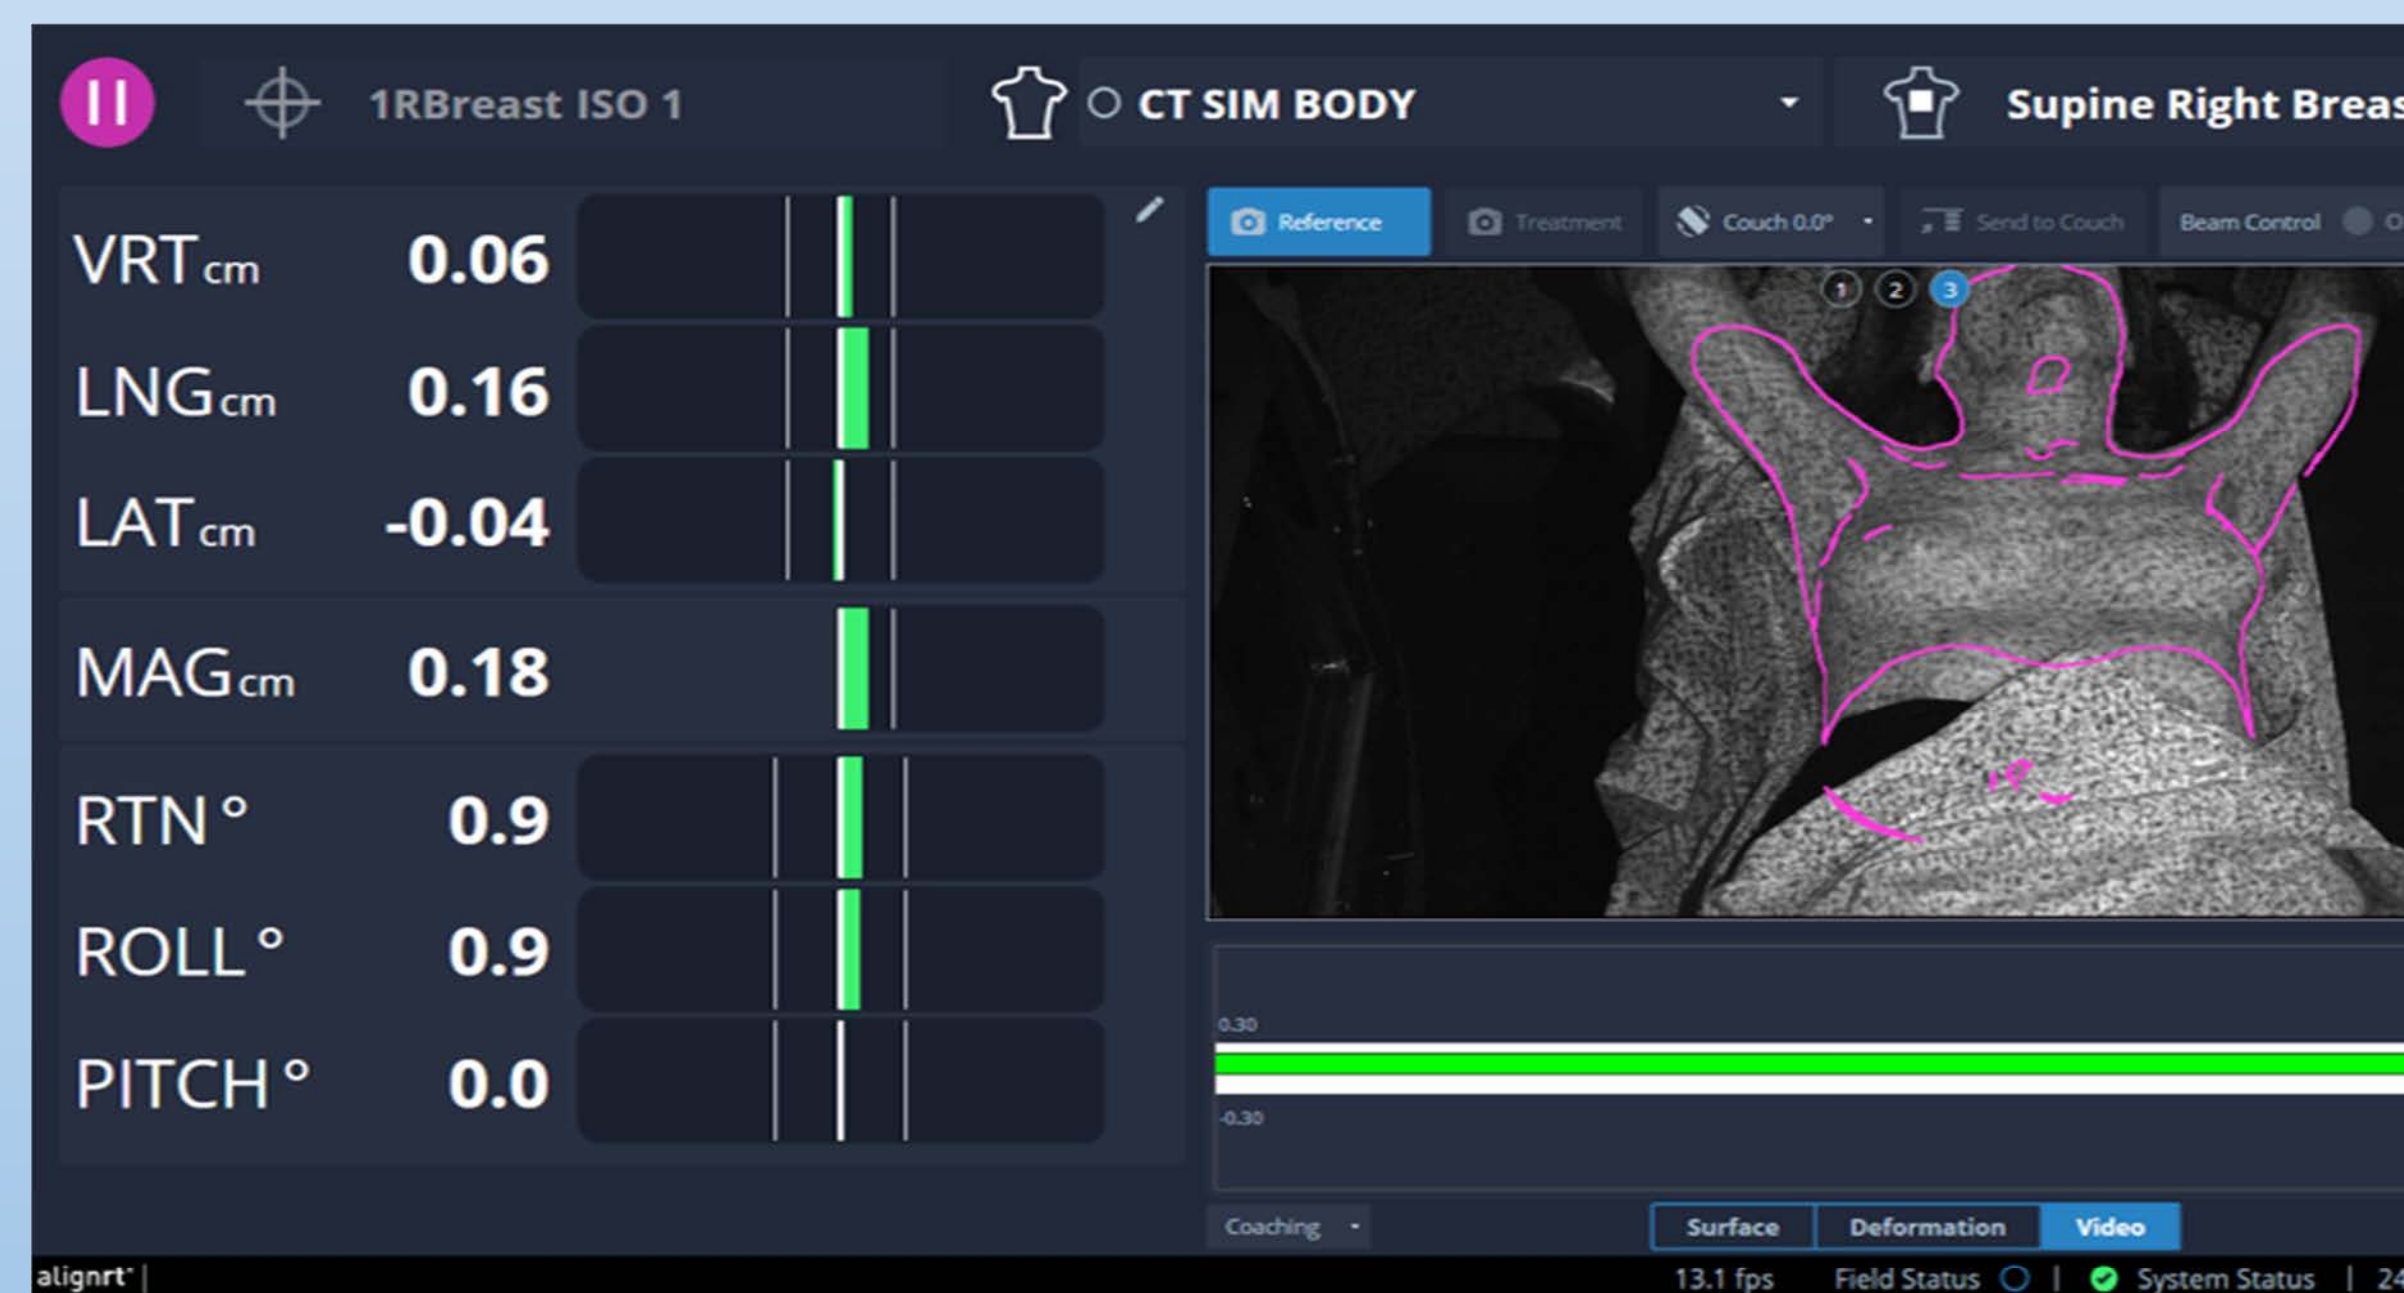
Surface guidance during DIBH using AlignRT system. DIBH treatment delivery will beam on when detected surface is within preset limits to reference CT data (magenta outline) and beam off if detected surface variation is outside tolerances.
